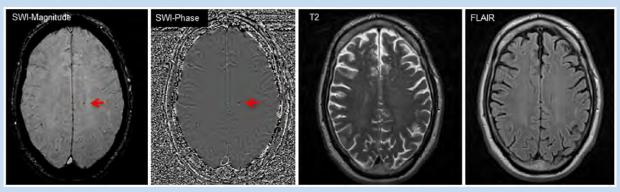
Microbleed in a 57-year-old player (patient 10). Both SWI magnitude and phase images detect an isolated microbleed at the subcortical gray matter/white matter (GM/WM) junction, while conventional FLAIR and T2-weighted images at the same level fail to visualize the microbleed. Red arrows point to a hemorrhagic lesion, which is not shown on the T2 and FLAIR images. FLAIR, fluid attenuated inversion recovery; SWI, susceptibility weighted imaging.
